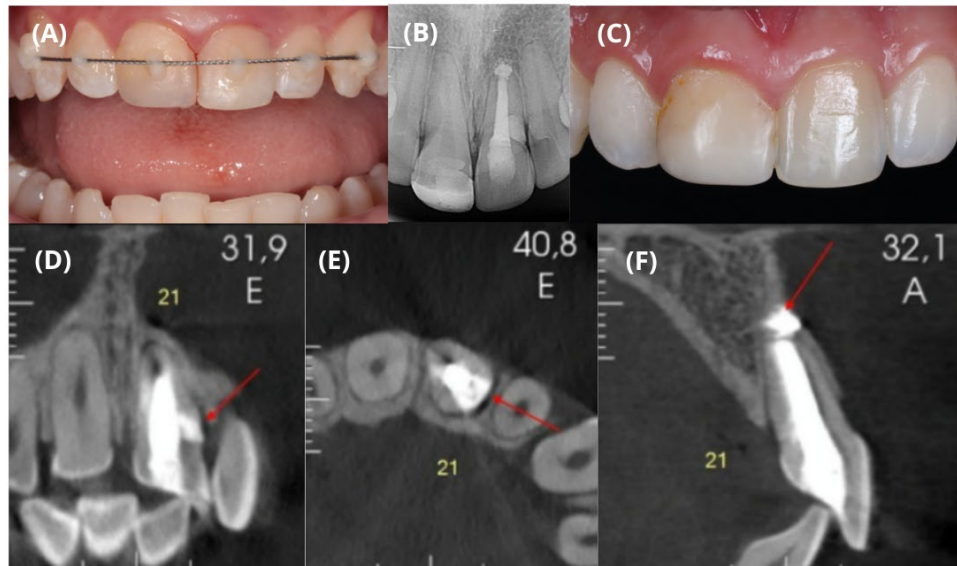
A) Flexible splinting of tooth #21; B) Radiographic appearance 3 years after surgery; C) Clinical appearance 3 years after surgery; D, E, and F) Coronal, axial, and sagittal tomography sections 3 years after surgery, respectively
